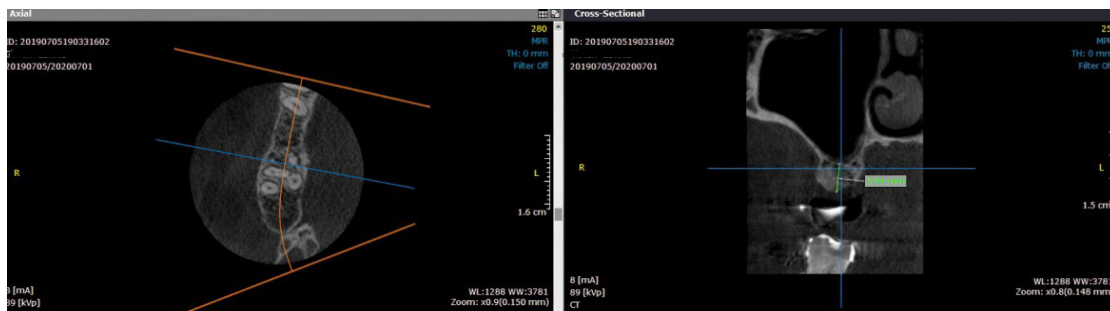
Preoperative CBCT evaluation of distal bone height of the edentulous site.
